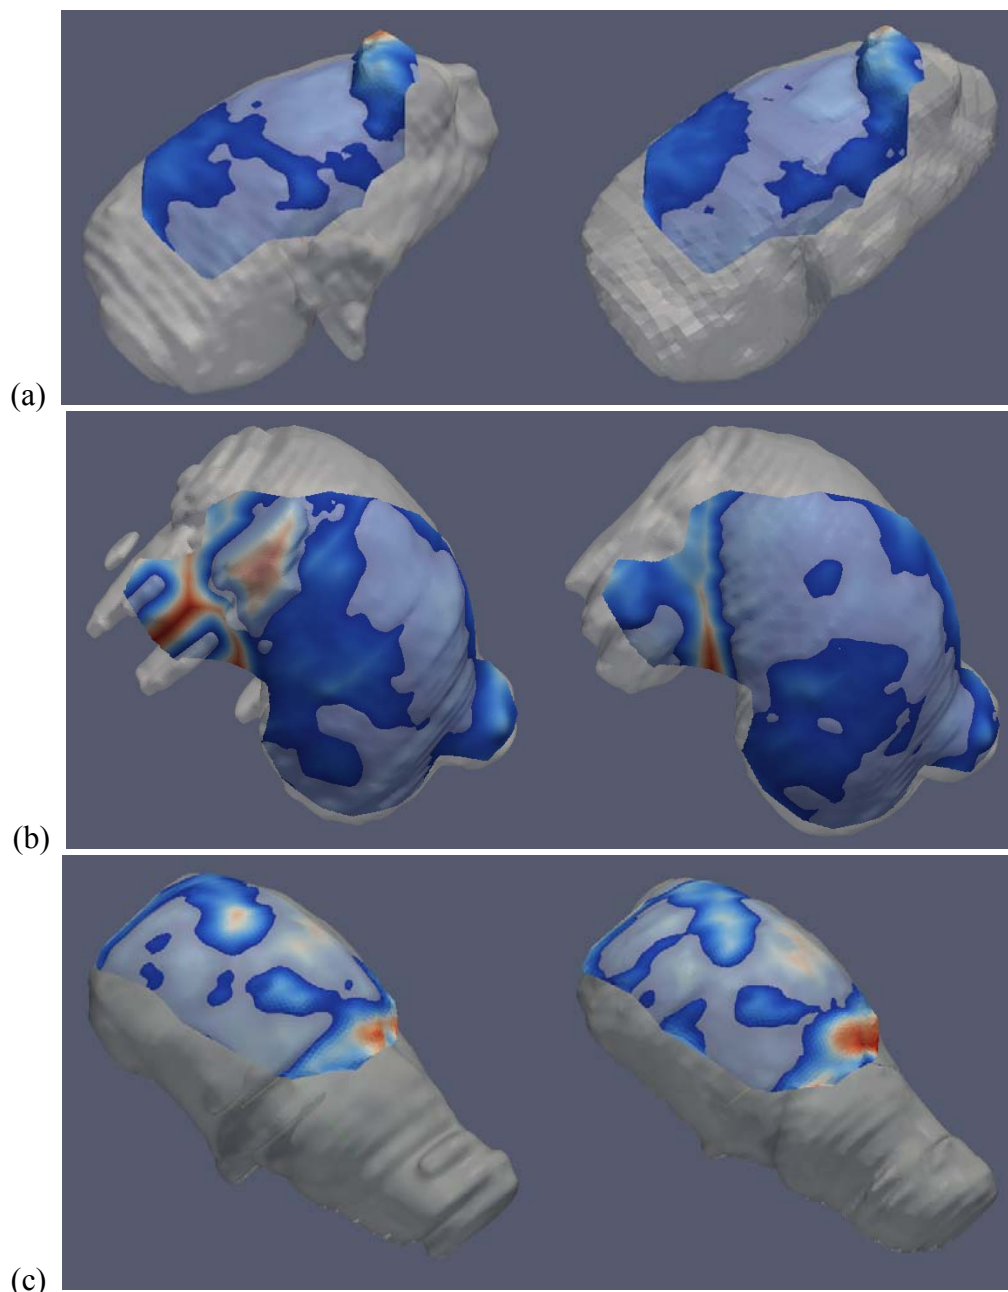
Preoperative CT and intraoperative laser range scans for three cases, (a-c). Registered laser range scan shown with autosegmented (left) and handsegmented (right) CT surfaces. Laser surface colors indicate closest point distances to the CT surface, with the highest distances visible as red.
